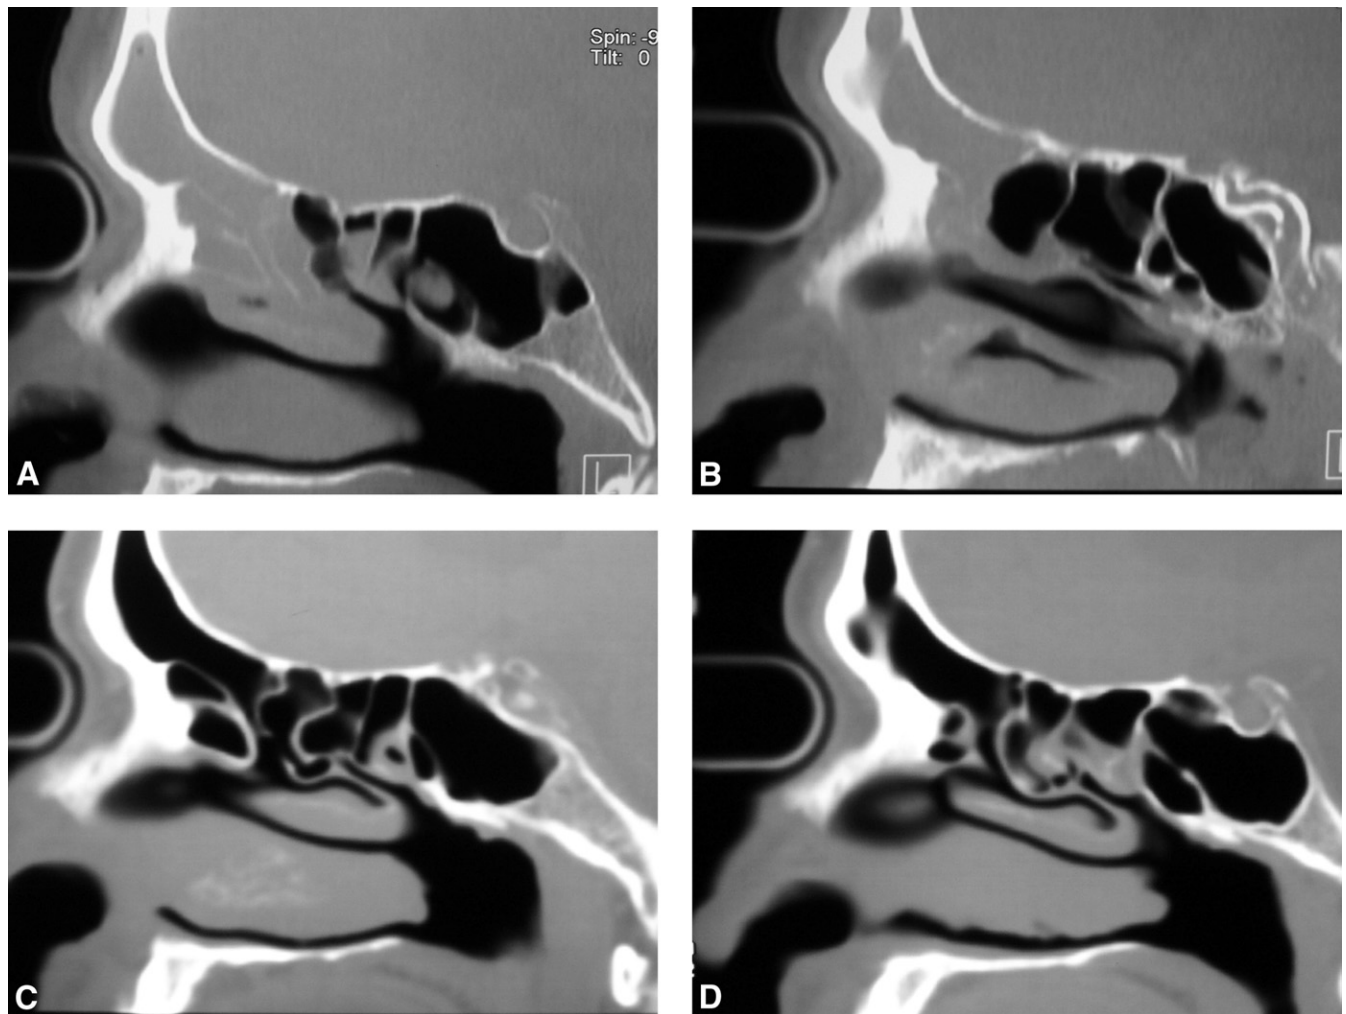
(A) Preoperative sagittal CT reconstruction, right side. (B) Preoperative sagittal CT reconstruction, left side. (C) Postoperative 1-year sagittal CT reconstruction, right side, comparable to 5A. (D) Postoperative 1-year sagittal CT reconstruction, left side comparable to 5B.
